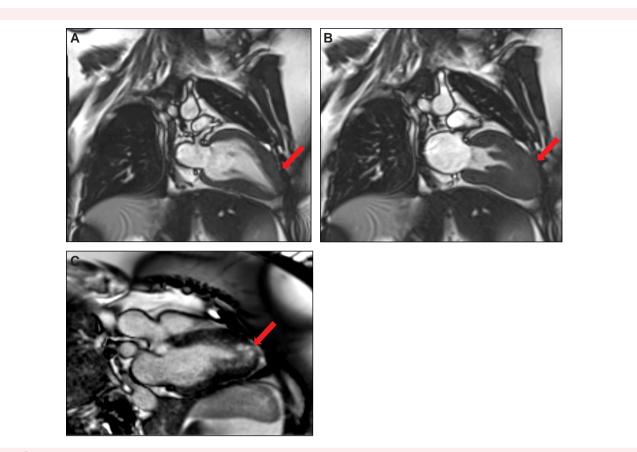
Cardiac magnetic resonance imaging showing apical hypertrophy in (A) diastole and (B) apical cavity obliteration in systole consistent with a diagnosis of hypertrophic cardiomyopathy. (C) Late gadolinium enhancement showing apical fibrosis.
